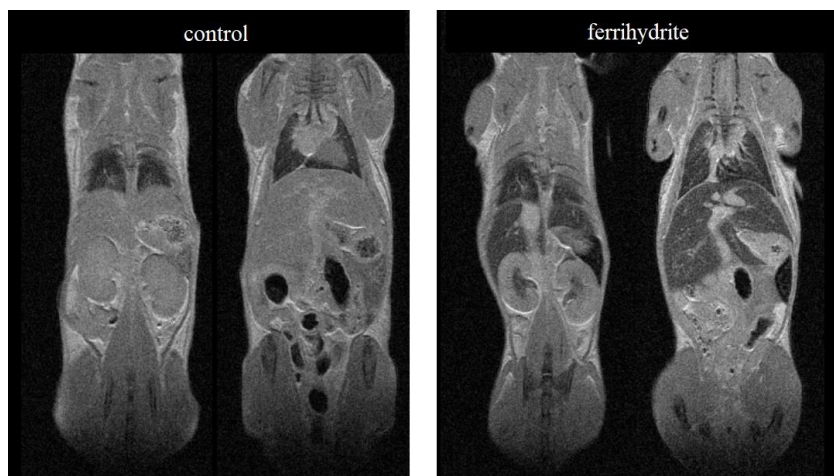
Ferrihydrite-mediated T2-weight contrast of liver, spleen and kidneys (MRI)
